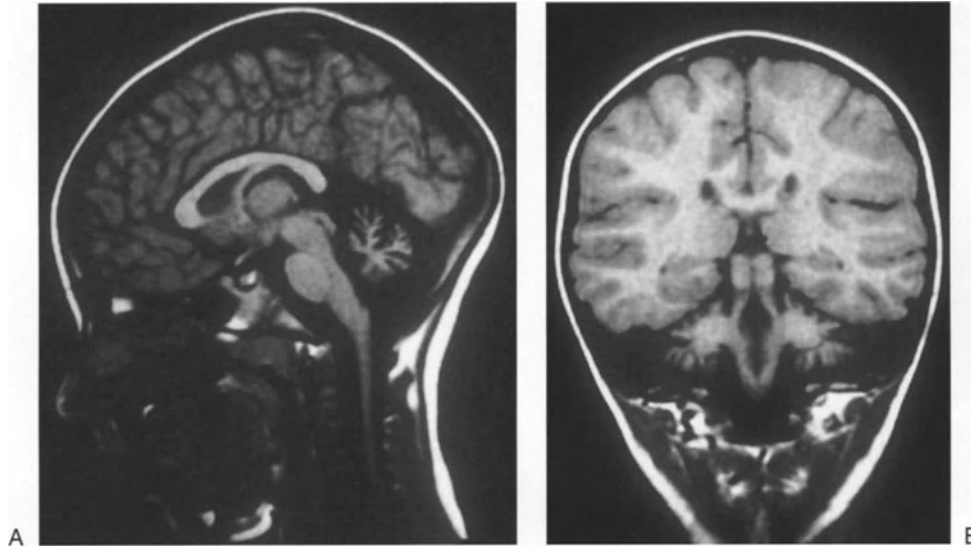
This T1 weighted MRI study in the sagittal (A) and coronal (B) sections reveals a rather remarkable degree of congenital cerebellar atrophy. It is interesting to note that by
